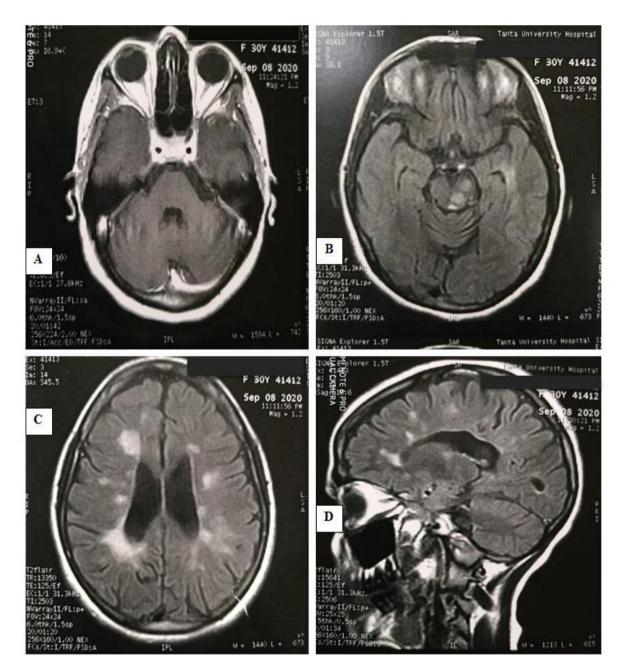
Female patient 30 years old, presented by left sided trigeminal neuralgia. MRI brain revealed: (A) axial T1WI, (B,C,D) axial & sagittal FLAIR images revealed multiple variable sized patches of altered signal intensity in the form of bright T2 & FLAIR signal seen in white matter on both deep tempro-parietal region & both centrum semiovale oriented perpendicular to corpus callosum and calloso-septal space (dowsn fingers), left side of midbrain. Multiple sclerotic plaques in a known case of MS
